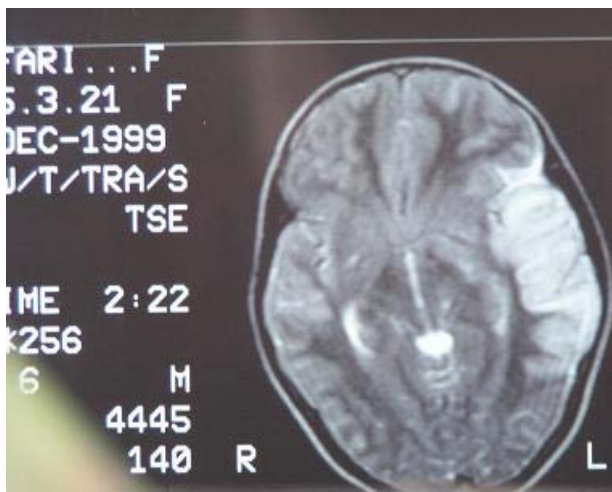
Brain MRI (edema and hyperintensity in temporal area T2W)
